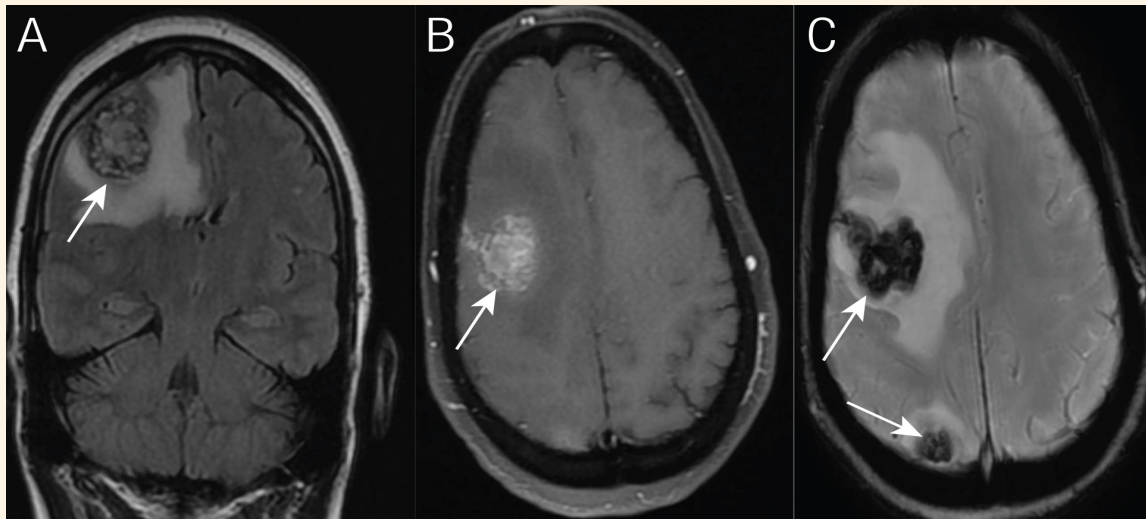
A: Coronal T2-weighted magnetic resonance imaging (MRI) revealing haemorrhagic lesion within the subcortical region of right parietal lobe measuring 2.7×2.2 cm with adjacent vasogenic edema (arrow); B: Axial contrast-enhanced T1-weighted MRI revealing multiple, enhanced, nodular lesions (arrow); C: Susceptibility weighted imaging demonstrating multiple hypointense, haemorrhagic lesions in the cortical and subcortical areas (arrows).
